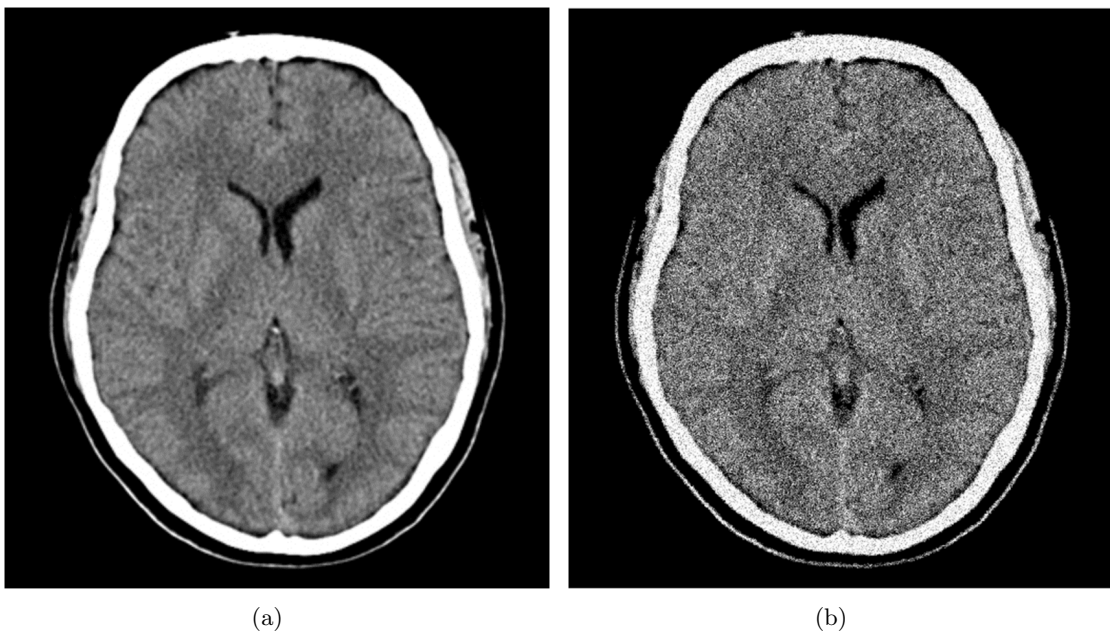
In (a) the low-contrast resolution allows the differentiation between the white and grey matter in a noise-free CT image; in (b) the presence of image noise drastically reduces low-contrast resolution and the white and grey matter are barely indistinguishable
